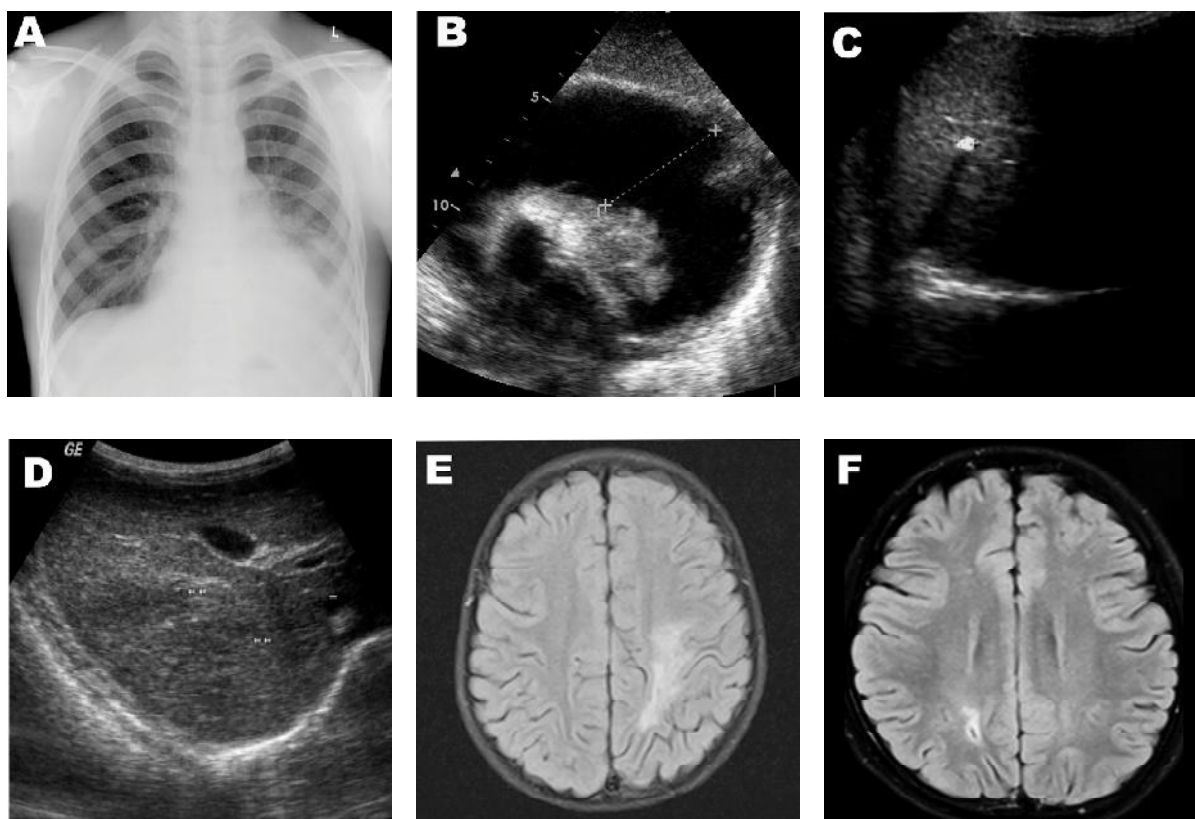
Imageology of patients. A. Chest radiograph shows pleural effusion and hydropericardium. B. Ultrasound shows hydropericardium. C. Ultrasound shows calcification in the right liver with a size of 0.4 cm. D. Ultrasound shows multiple low echogenic areas in the liver. E. MRI shows a long T1 and T2 signal area in the left temporal and apical lobes. F. MRI shows slight long T1 and T2 signal area with obscure boundary in the right parietal lobe. Stick shape with hyposignal was noted within this area
